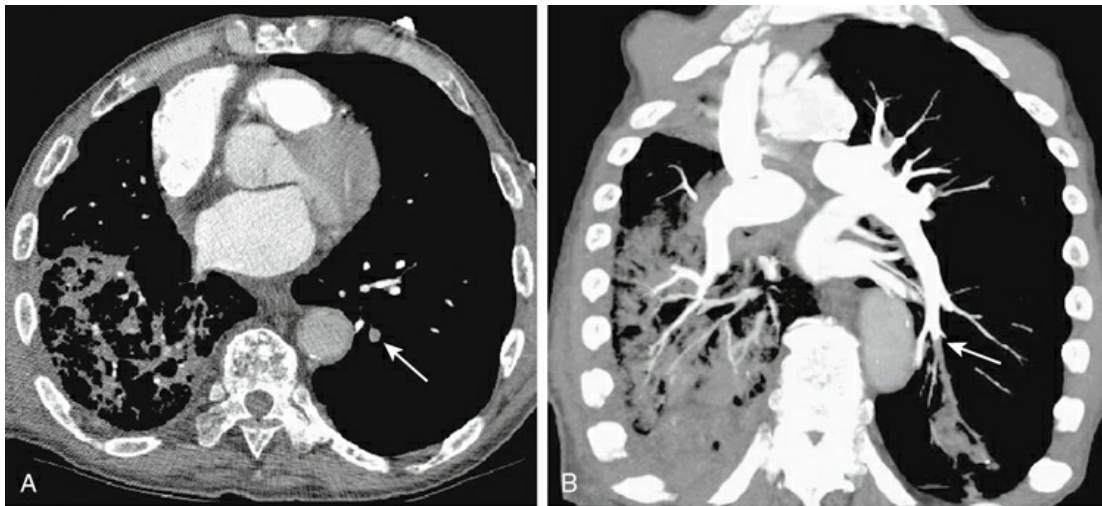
Chest computed tomographic angiography shows pulmonary embolus in the mid-sized vessel in the left lung. A, Standard cross-sectional view shows a blood vessel (seen on end) filled by a clot rather than radiopaque contrast dye (*arrow*). B, Image displayed in a reformatted oblique view shows the same vessel in its longitudinal course. The *arrow* marks the absence of radiopaque dye in the vessel at the edge of the clot.
